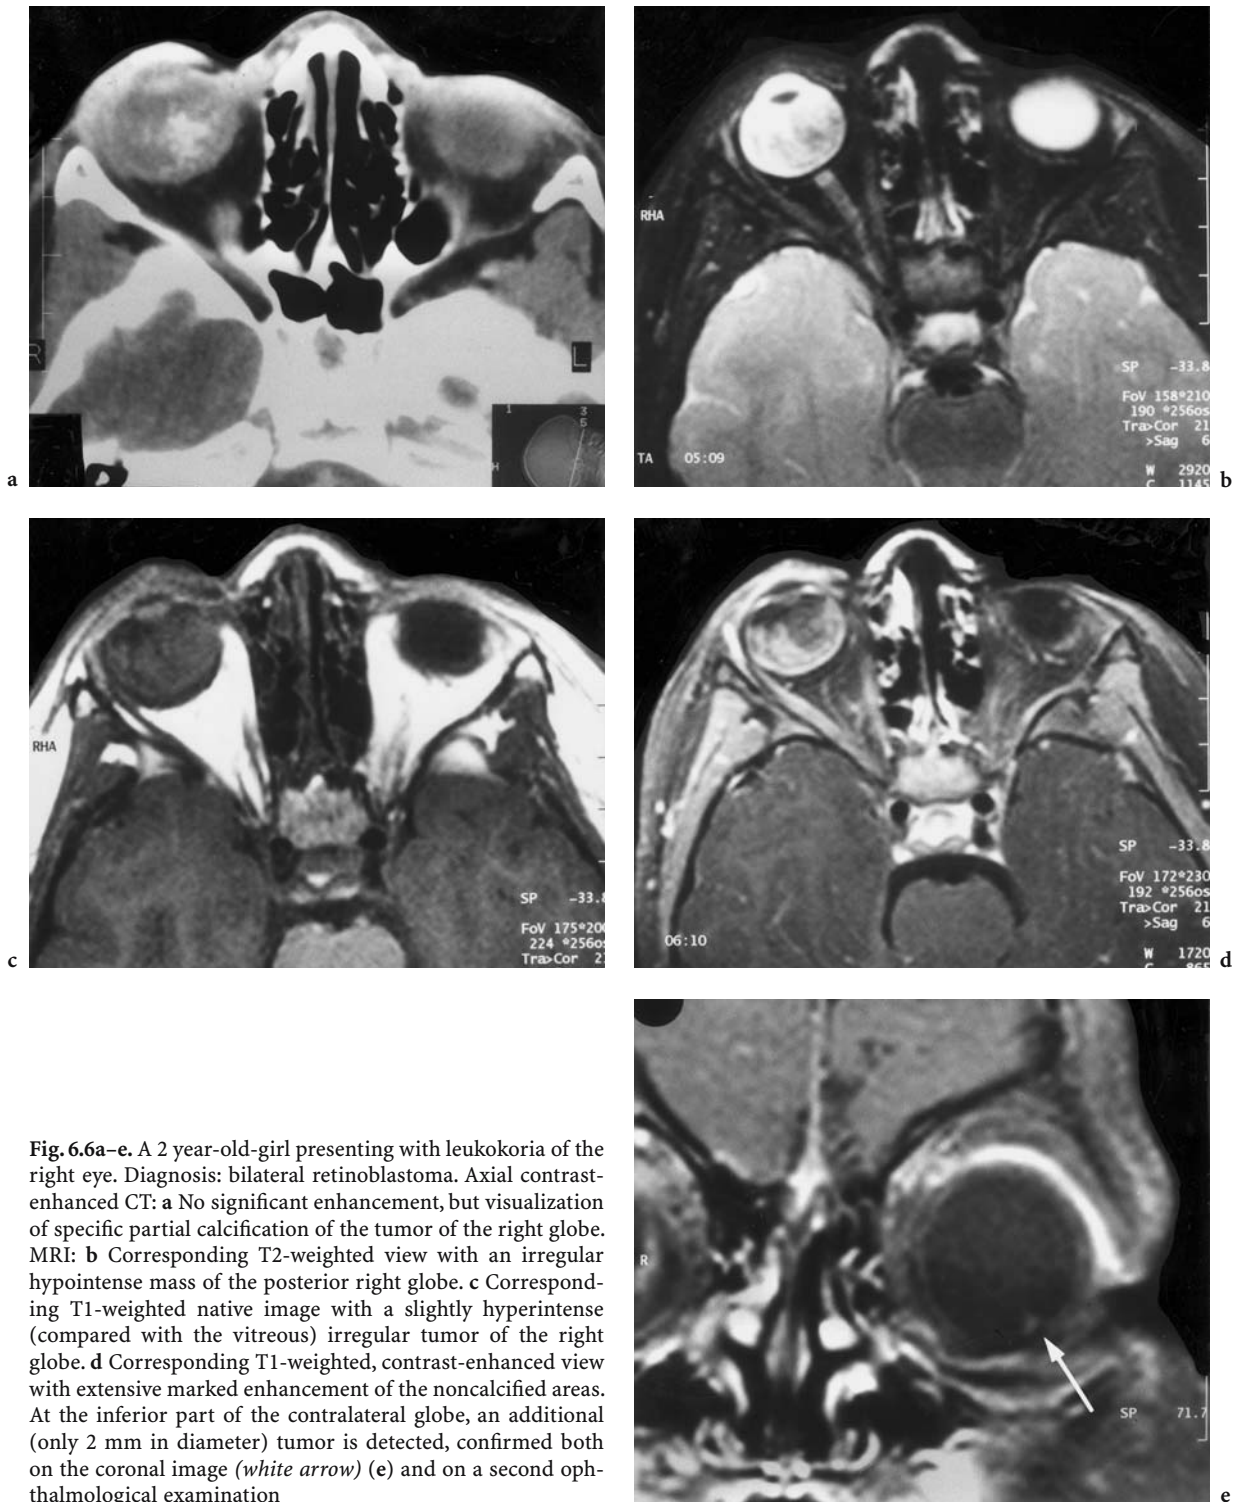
A 2 year-old-girl presenting with leukokoria of the right eye. Diagnosis: bilateral retinoblastoma. Axial contrast-enhanced CT: a No significant enhancement, but visualization of specific partial calcification of the tumor of the right globe. MRI: b Corresponding T2-weighted view with an irregular hypointense mass of the posterior right globe. c Corresponding T1-weighted native image with a slightly hyperintense (compared with the vitreous) irregular tumor of the right globe. d Corresponding T1-weighted, contrast-enhanced view with extensive marked enhancement of the noncalcified areas. At the inferior part of the contralateral globe, an additional (only 2 mm in diameter) tumor is detected, confirmed both on the coronal image (*white arrow*) (e) and on a second ophthalmological examination
